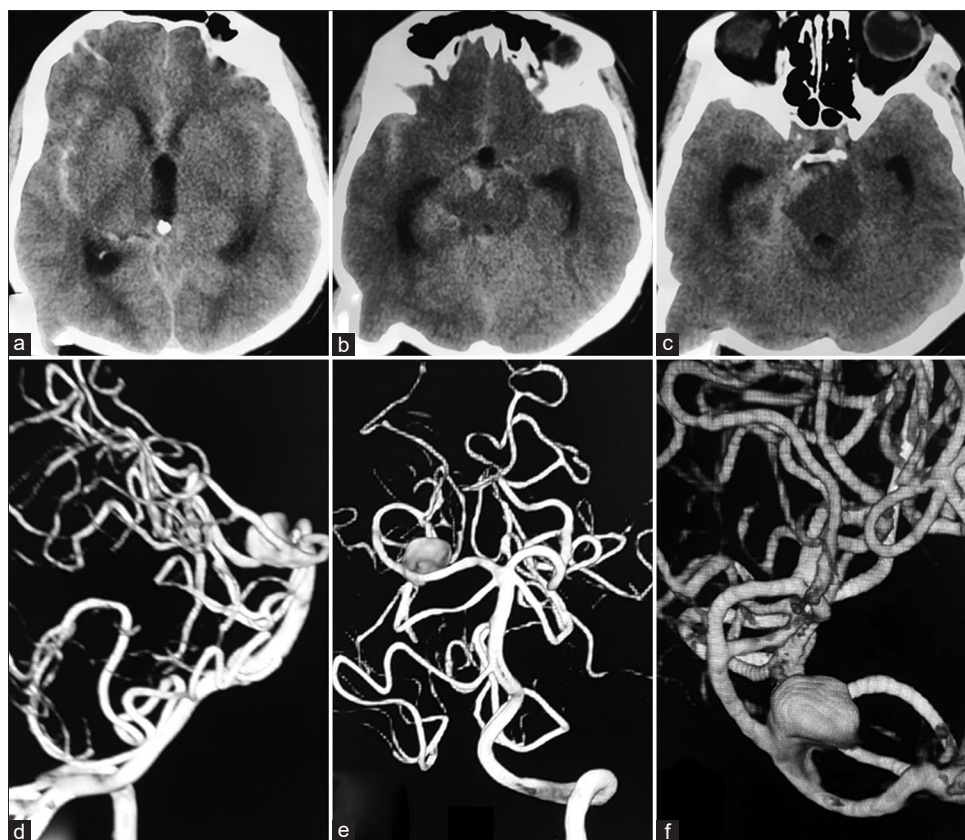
Non-contrast axial CT head revealing diffuse subarachnoid hemorrhage (a); non-contrast axial CT head revealing an elliptical hyperdense signal occupying the right upper quadrant of midbrain, possibly representing the dissected segment (b); preferential distribution of subarachnoid hemorrhage in the right basal cistern having localization value (c). Both B and C have associated features of early hydrocephalus; 3D rotational angiography (3DRA) of left vertebral artery (LVA) profiling the dissected pseudoaneurysm in lateral view (d); 3DRA of LVA profiling the dissected pseudoaneurysm in AP view (e); 3DRA of LVA profiling the dissected pseudoaneurysm in the broad base and its location in the P1–P2 junction (f)
